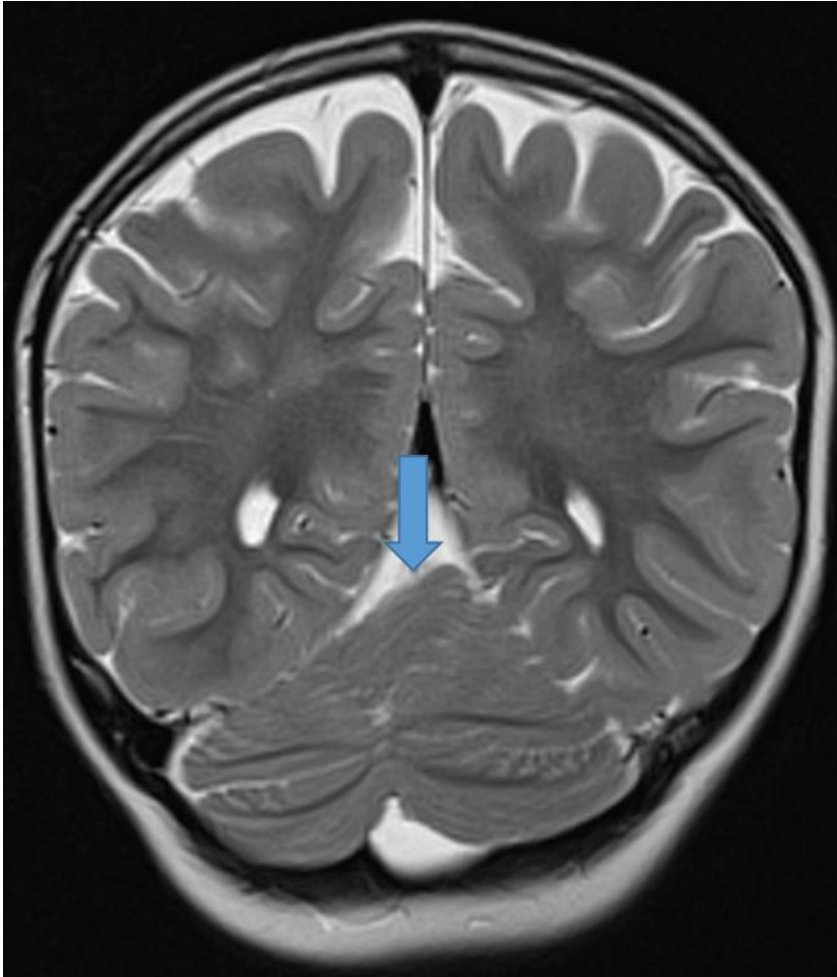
Coronal section from a brain MRI of individual A:II-1. Note a partial rhombencephalosynapsis of the superior posterior cerebellar hemispheres (blue arrow) while the inferior and anterior parts of the cerebellar hemispheres are separated and the vermis is regular.
